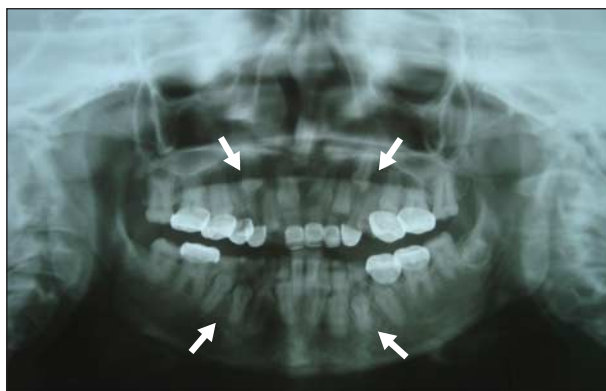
Panoramic dental radiographic scan showing the unerupted teeth of a 16-year-old girl.
